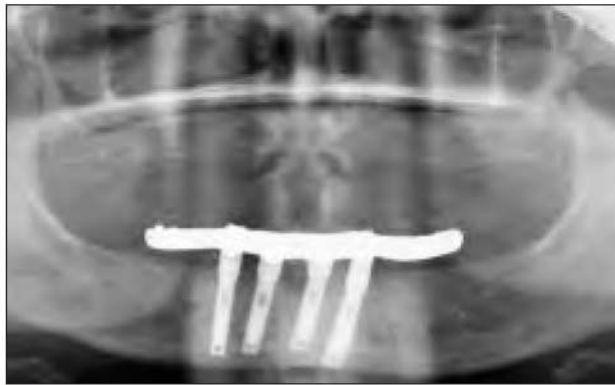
Panoramic radiograph of a patient in the sample, obtained in 1988.
